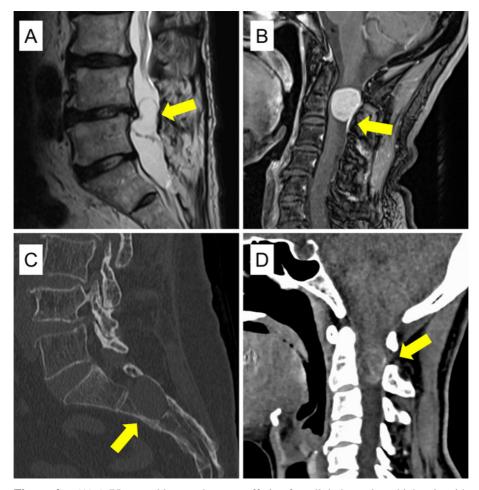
(A) A 75-year-old man who was suffering from light buttock to thigh pain with spinal schwannoma with cystic change (arrow), showing iso-intense signal to cerebrospinal fluid on sagittal T2WI. (B) A 57-year-old woman who was suffering from neck pain and right-hand numbness with spinal meningioma with diffuse enhancement and dural tail sign (arrow) on sagittal Gd-enhanced T1WI. (C) A 76-year-old who was suffering from dysuria with sacral bone showed scalloping (arrow) with a dorsal cortical defect on the CT sagittal view. (D) A 57-year-old woman who was suffering from neck pain and right-hand numbness with spinal meningioma with immature soft tissue calcification on the CT sagittal view.
